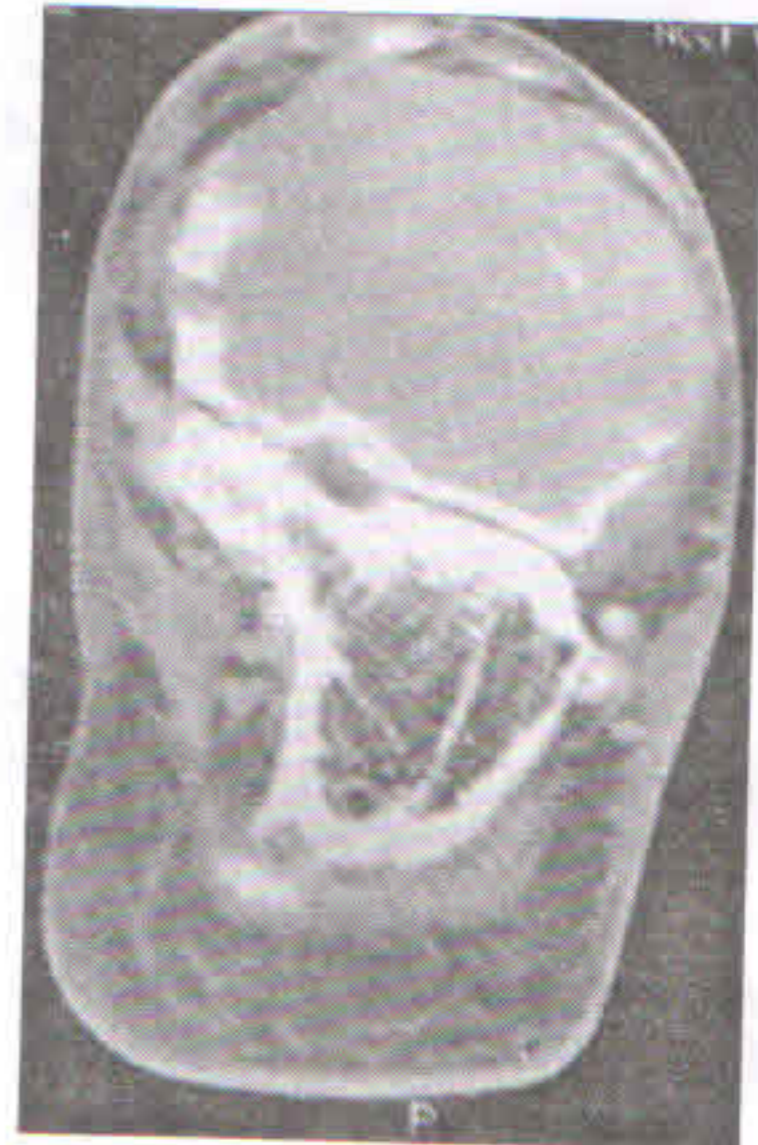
CT scan of ankle showing an expansile lytic lesion in the talus causing cortical destruction and extending into soft tissues.
